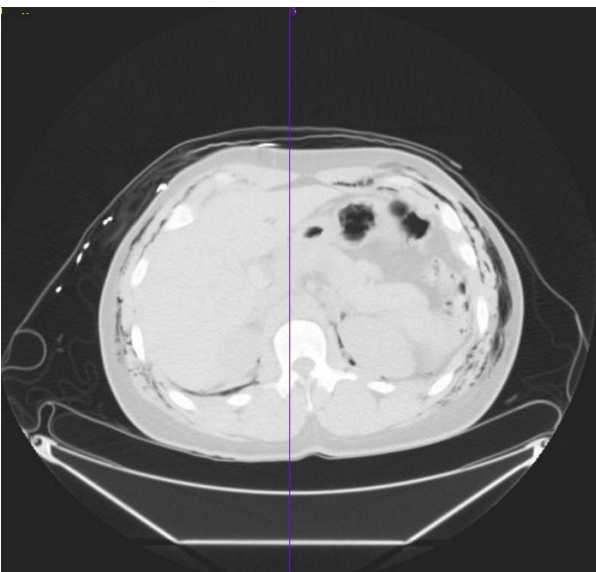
Axial view of CT abdomen showing punctate retroperitoneal air around left kidney.
